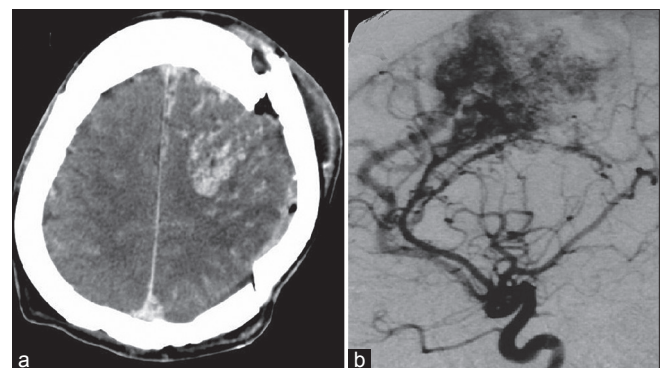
(a) Contrast-enhanced CT showing an enhancing nidus in the left frontal area. (b) Digital subtraction angiogram showing the arteriovenous malformation fed by branches of the anterior cerebral artery and middle cerebral artery
